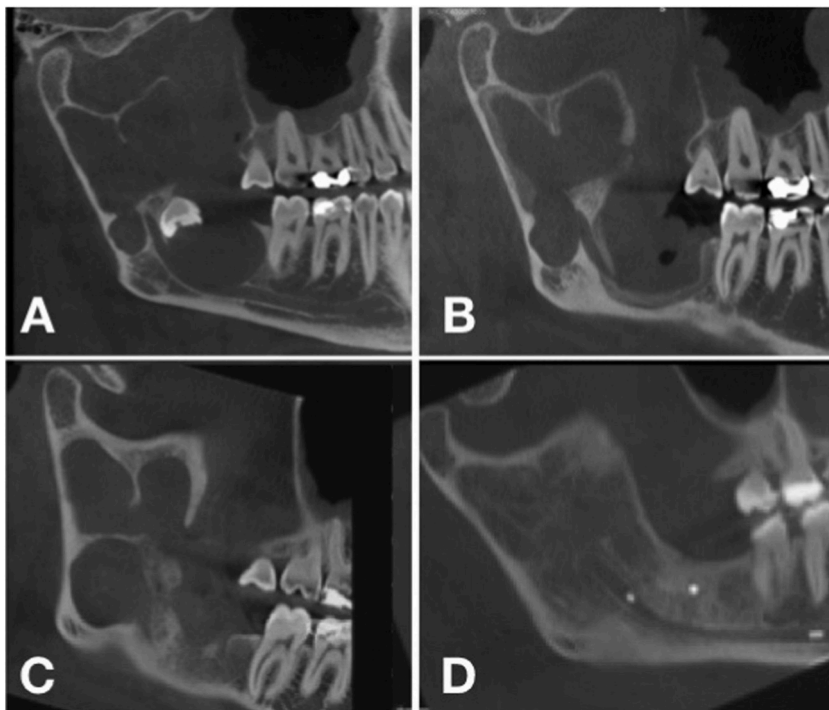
Radiographic images of the multilocular odontogenic keratocyst (OKC): A) CBCT scan at the radiographic diagnosis: the lesion appears as multilocular, includes part of the impacted third molar and involves the IAN; B) CBCT scan 8 months after marsupialization (first surgical approach) with signs of bone deposition and progressive reduction in lesion volume; C) Radiographic control (CBCT) 20 months after marsupialization showing as the lobe of the OKC located on the posterior border of the mandible was increasing instead of diminishing; D) CBCT scan taken 12 months from the second surgical treatment (radical excision) with a good bone healing and incorporation of the osteosynthesis plate. CBCT= Cone Beam Computed Tomography, IAN = Inferior Alveolar Nerve, OKC = Odontogenic Keratocyst.
